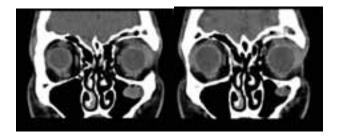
Preoperative CT scan in axial view, after craniofacial injury. Comminuted fracture that involves the left orbital roof with intraorbital bone fragment.
